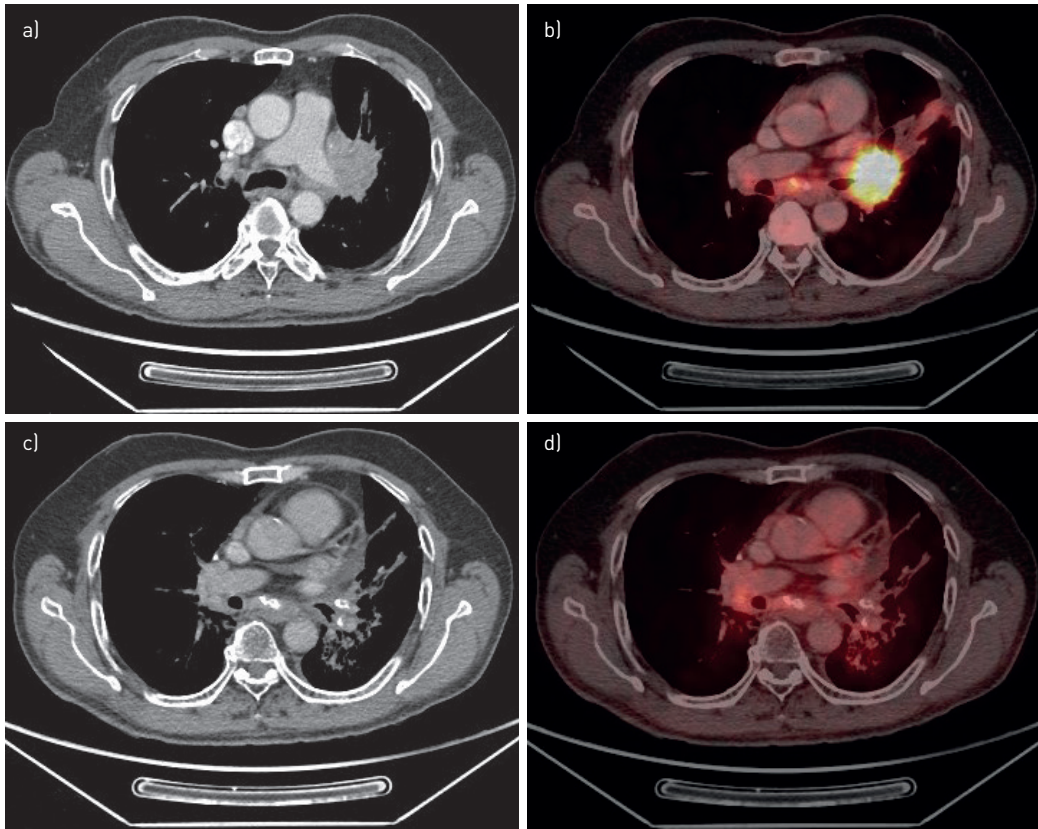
a) Chest CT showing a lobulated necrotic mass in left hilar region with foci of calcifications and spiculated margins at the time of diagnosis. b) PET-CT carried out at the time of diagnosis showing FDG uptake with a SUV of 14.5; an FDG avid (SUV 5.9) subcarinal lymph node is also shown in the image. c) CT carried out 12 months later showing resolution of the hilar mass. d) PET-CT carried out 12 months later showing reduced uptake in the subcarinal lymph node.
